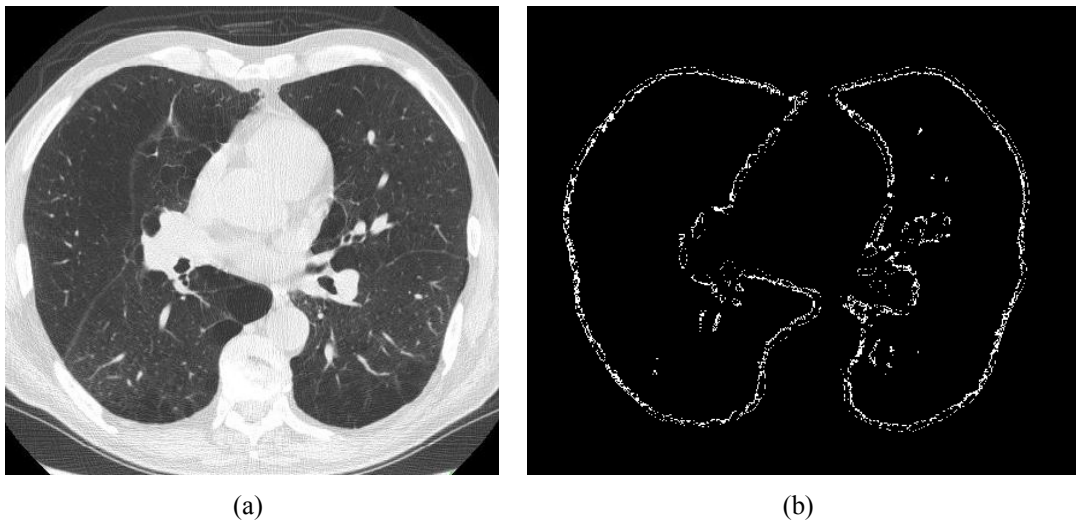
(a) Original HRCT lung image (b) Corresponding α -image
